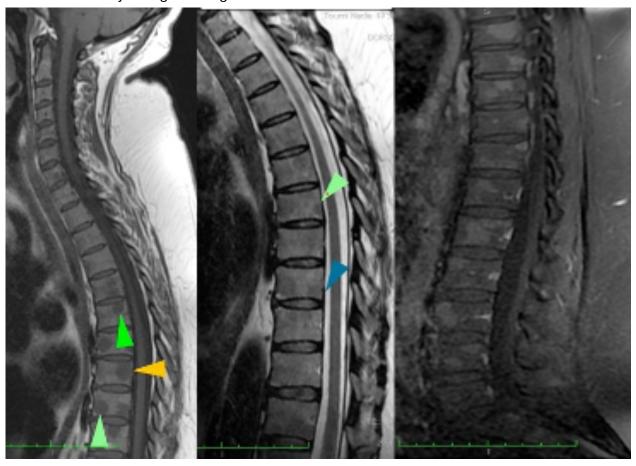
Appearance of bone lesions on spinal MRI: T1 and T2 hypointense signal and STIR hyperintense signal.
